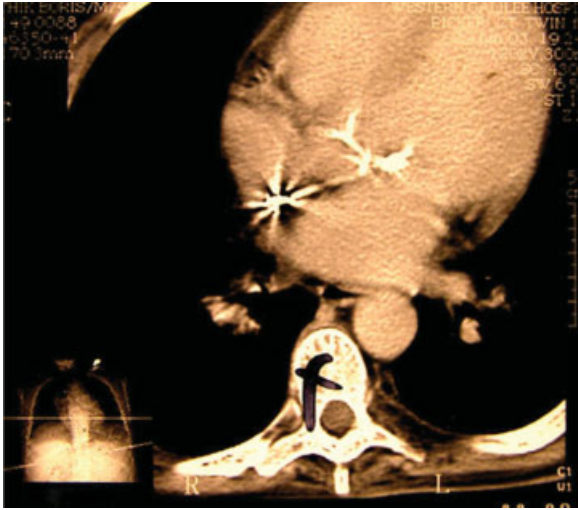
Computed tomography scan of chest, with evidence of heavy calcification of coronary arteries and mitral annulus calcification.
